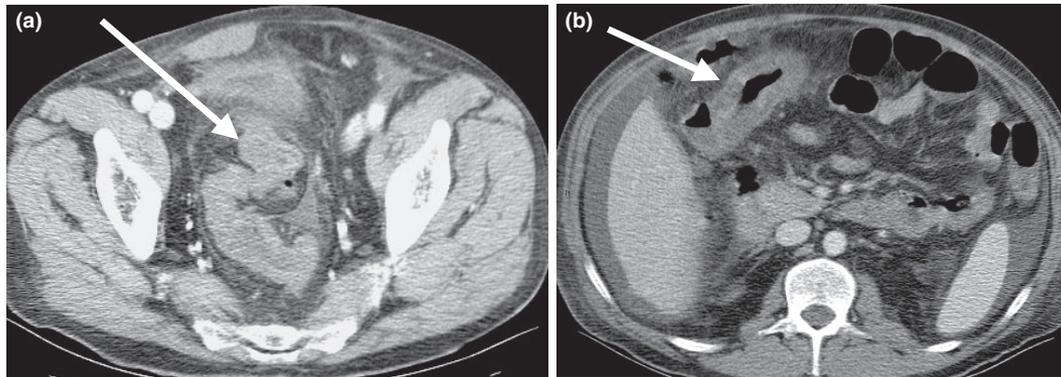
(a) CT scan: thickening of the wall of the sigmoid colon and rectum (arrow). (b) CT scan: thickening of the wall of the ascending colon (arrow), free air and perihepatic fluid collection.
